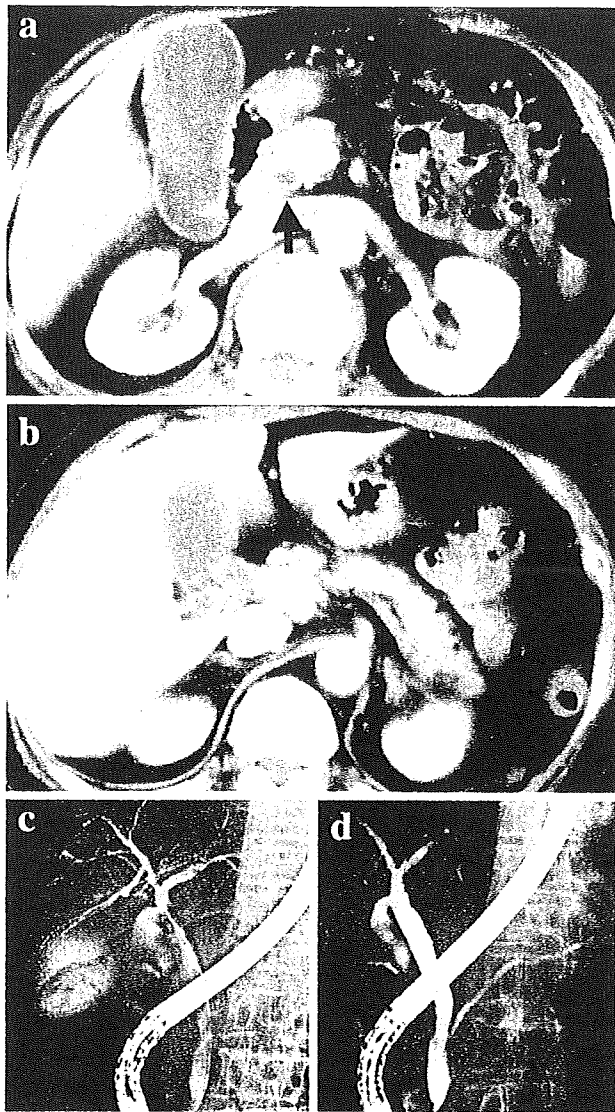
Abdominal computed tomography (CT) images of case 2 on clinical onset. Abdominal CT showed a dilatation of common bile duct (a) and no significant pancreatic lesions (b), such as swelling of the pancreas. ERCP revealed irregular narrowing of the intrahepatic bile duct (c), and no narrowing of the main pancreatic duct (d)
